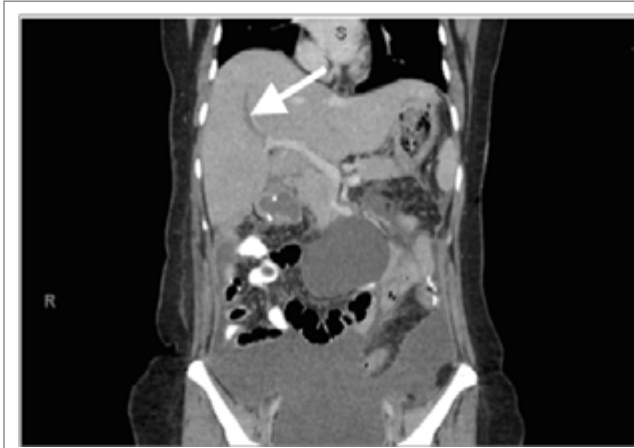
Contrast enhanced computed tomography (CT) image showing thrombosis of the anterior branch of right portal vein
